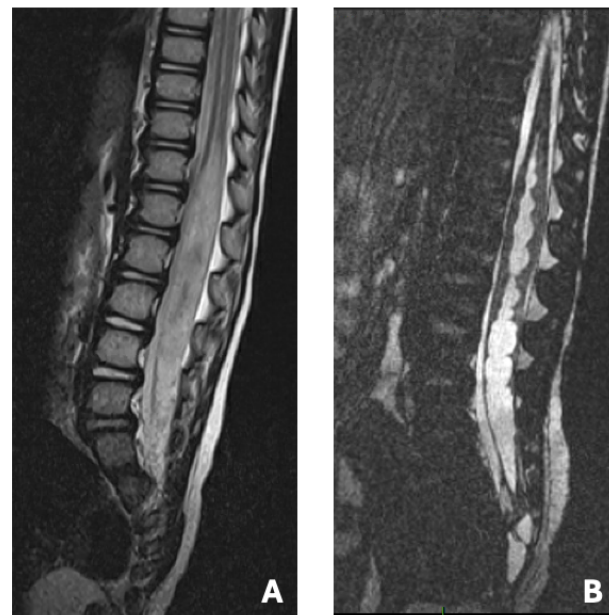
MRI findings at subacute worsening showing an extensive syringomyelia
